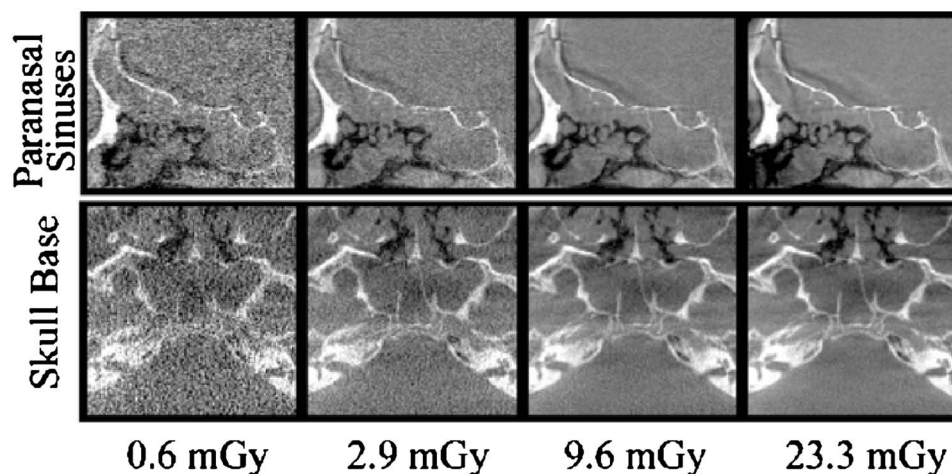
Effect of CBCT dose on bony anatomy visualization:* Sagittal images of the paranasal sinuses (including the frontal sinus, ethmoid air cells, cribriform plate, pituitary gland, sphenoid sinus, and clivus) and axial images of the skull base (including the sphenoid sinus and clivus) from 3D volume reconstructions across a range of imaging dose (0.6–23.3 mGy).
